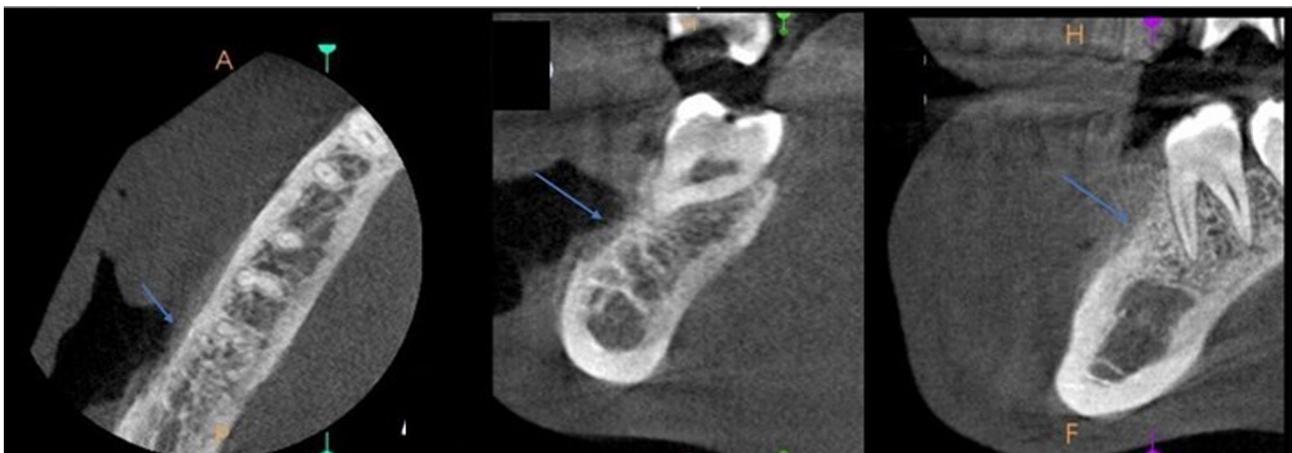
Axial, coronal and sagittal sections of CBCT showing erosion of buccal and lingual cortex.
